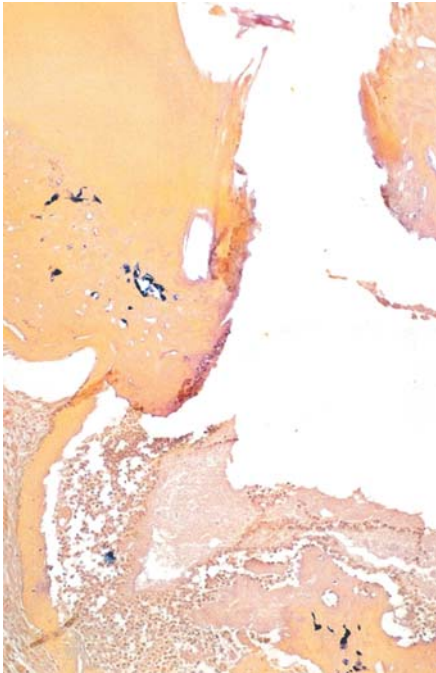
Microorganisms in the superficial cementum and periapical region, Brown & Brenn - 125X
